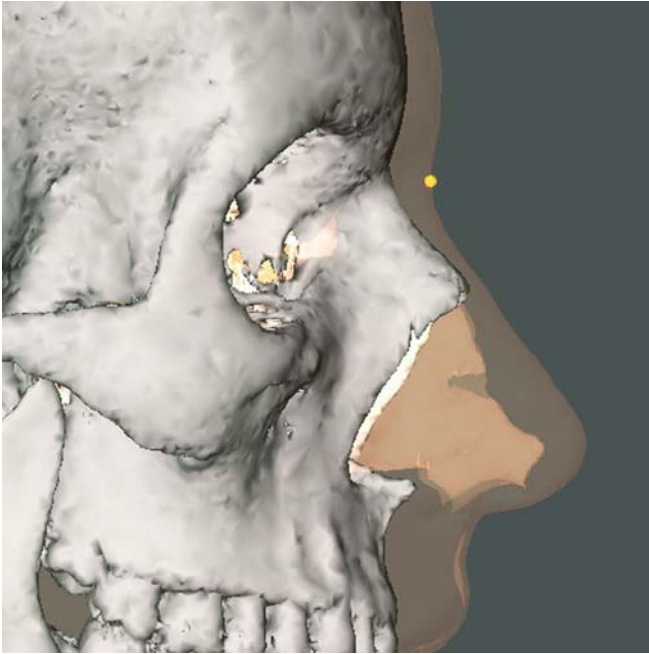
Sellion. Profile view right. Note that sellion is usually situated more inferiorly than soft tissue nasion (3-D CT, transparent soft tissues, patient K.C.)
